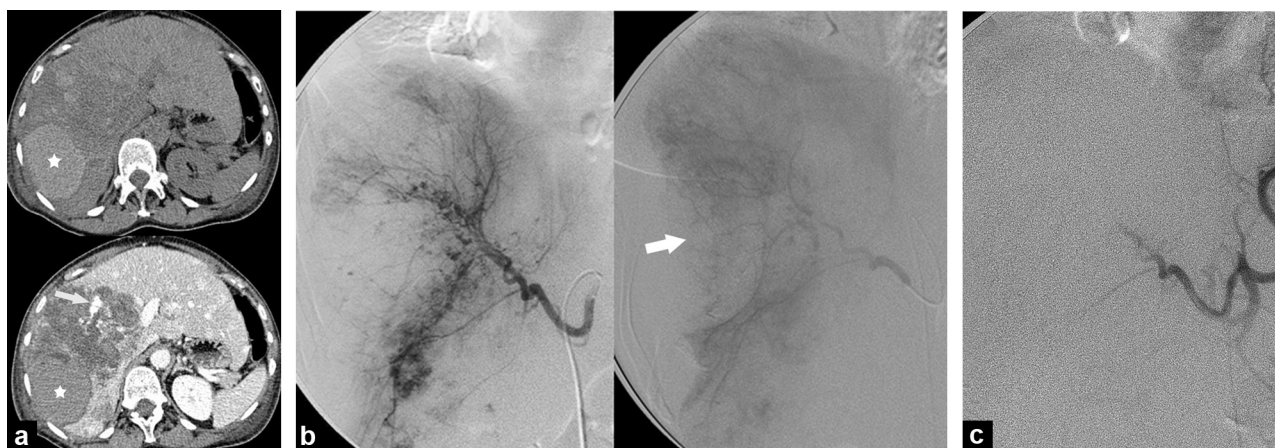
Spontaneous bleeding of a hepatic angiosarcoma: a: abdominal CT before and after contrast enhancement. Heterogeneous hypovascularized mass with blood lakes (arrow) combined with an intrahepatic hematoma (star); b: in the arterial phase (left image), arteriography shows predominantly peripheral enhancement appearing as blood lakes. In the venous phase (right image) the avascular zone (arrow) persists and shows the intra-hepatic hematoma; c: post-treatment appearances after embolization with resorbable particles.
